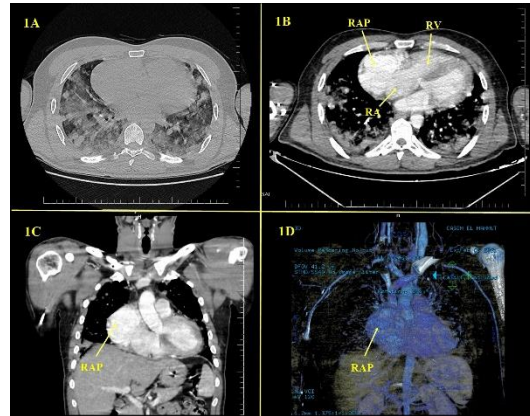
HRCT and Contrast enhanced CT views; A) An axial HRCT image, diffuse mixed ground-glass and consolidative opacities; B) An axial contrast enhanced CT image, large RAP with mural thrombus and bilateral multiple lung nodules; C) A coronal contrast enhanced CT image shows RAP; D) A 3-dimensional CT image shows RAP.
